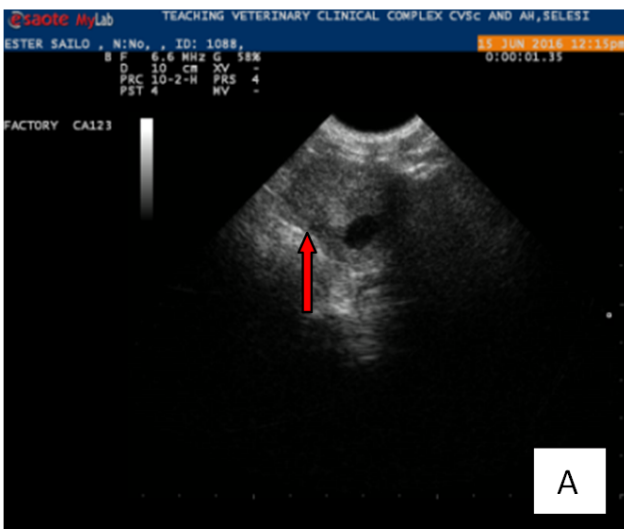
Sagittal sonogram of prostate revealed mildly irregular shaped prostate (3.73 cm), loss of normal bilobed appearance with centrally located anechoic dilated urethra (A). Presence of clear anechoic three intra-prostatic cysts (B)
